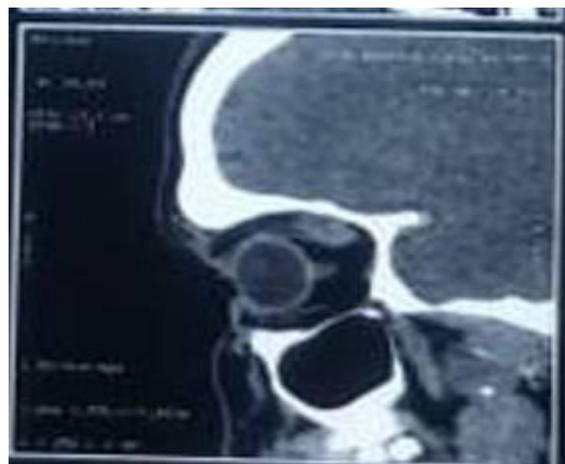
CT Scan sagittal image showing cyst in superior rectus muscle.
